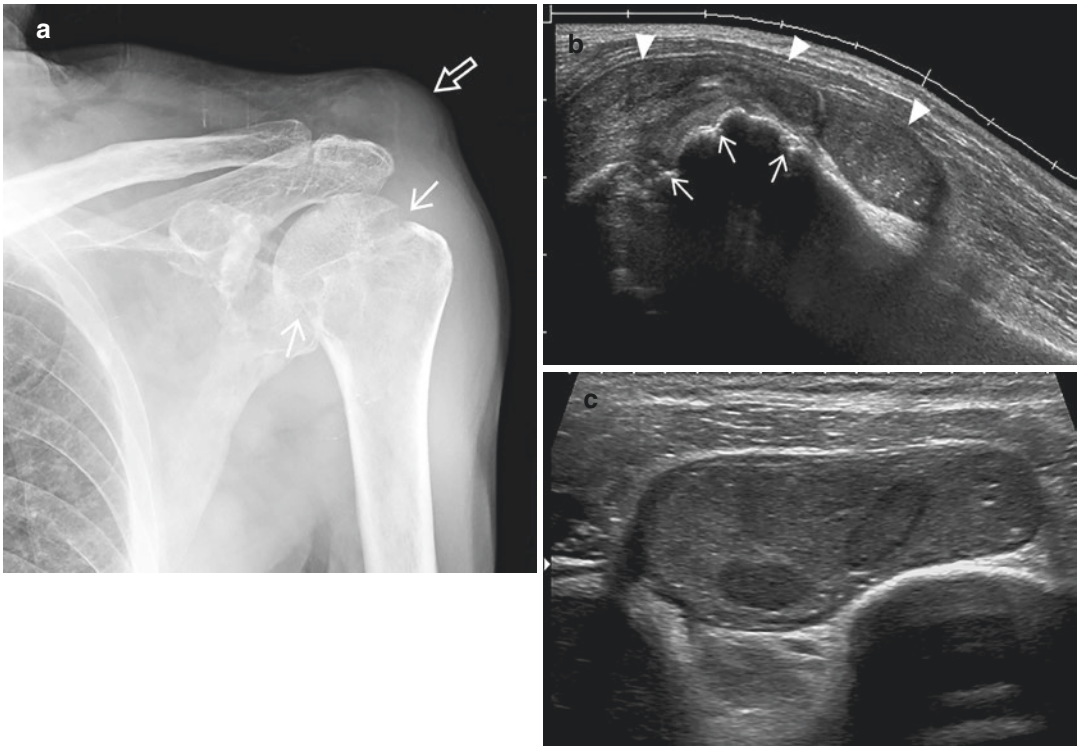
Tuberculous arthritis of the left shoulder with subdeltoid bursitis in a 68-year-old man who had left shoulder pain for 10 months. (a) Frontal radiograph shows bone erosions (arrows) in the humeral head and soft tissue swelling (open arrow) superior to the shoulder joint. (b)
